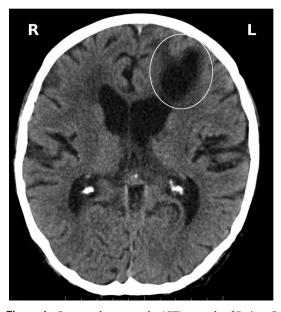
Computed tomography (CT) example of Patient C (male, 59 years old). There is a cystic lesion (white circle, top right) close to the anterior horn of the left lateral ventricle. This is a special case because the lesion is located very much in the front of the patient's brain.
